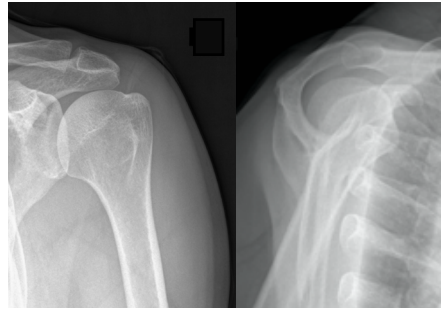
Normal X-ray of the shoulder
